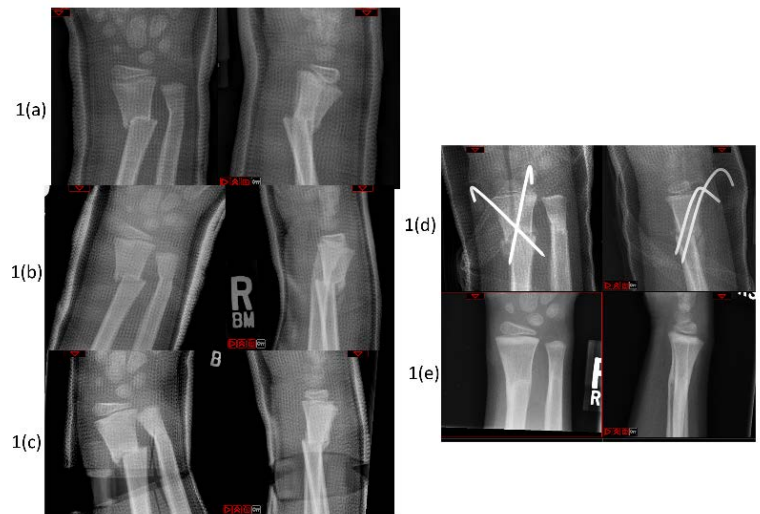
A 6-year-old boy with distal radius fracture. Radiographs at one week (a), reduced again with nitrous sedation (b), wedged after coronal plane deemed unacceptable (c), then went to OR for pinning (d). Final X-rays, healed (e)
